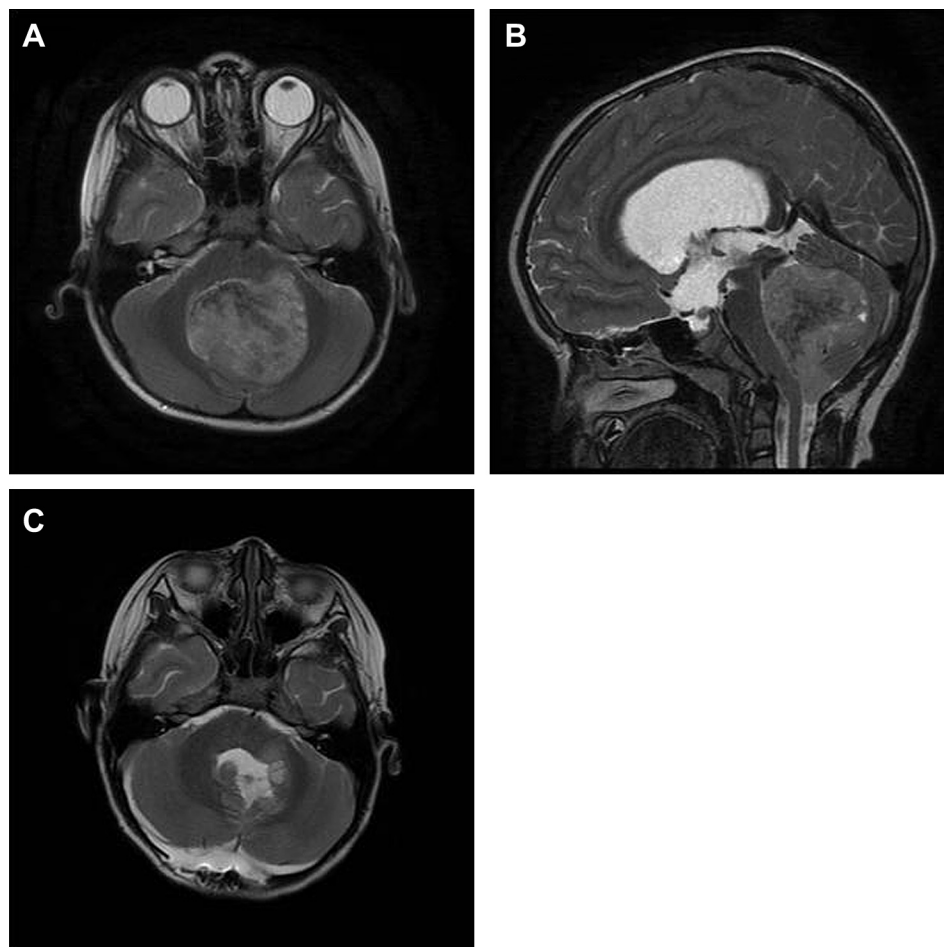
Pre- and postoperative brain magnetic resonance imaging of Case 2. (A and B) The preoperative image reveals a 5.4 cm × 4.6 cm × 4.4 cm tumor within the fourth ventricle extending to the left foramen of Luschka with diffusely enlarged lateral and third ventricles resulting in obstructive hydrocephalus. (C) Medulloblastoma has been documented by pathology. The post-operative image shows near-total excision of the tumor and improvement of hydrocephalus.
